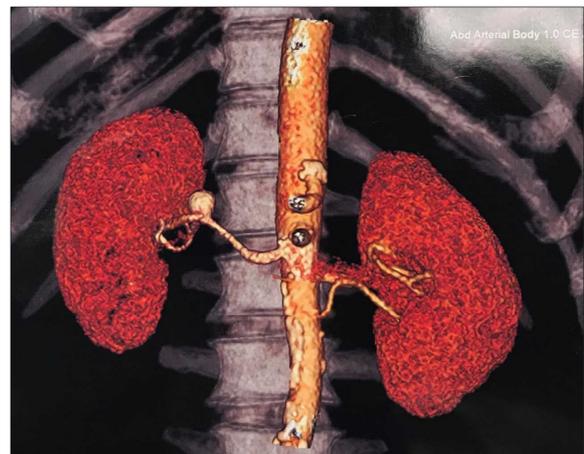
CT renal angiogram reconstructed image showing 2.2 cm extra-parenchymal renal artery aneurysm in the left kidney.
